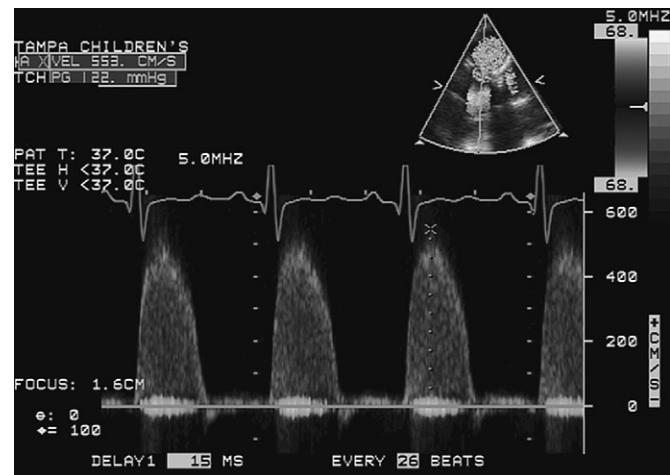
Left*, The rate of upstroke of mitral regurgitation is quantified by measuring the time from the 1 to the 3 m/s points on the waveform, in this example 15 ms. $dp/dt = 32 \text{ [1] } 15 \text{ ms} \times 1000 = 2133 \text{ mm Hg/s}$, which is normal. *Right*, Mitral regurgitation from an apical view with alignment of the continuous-wave Doppler cursor.
